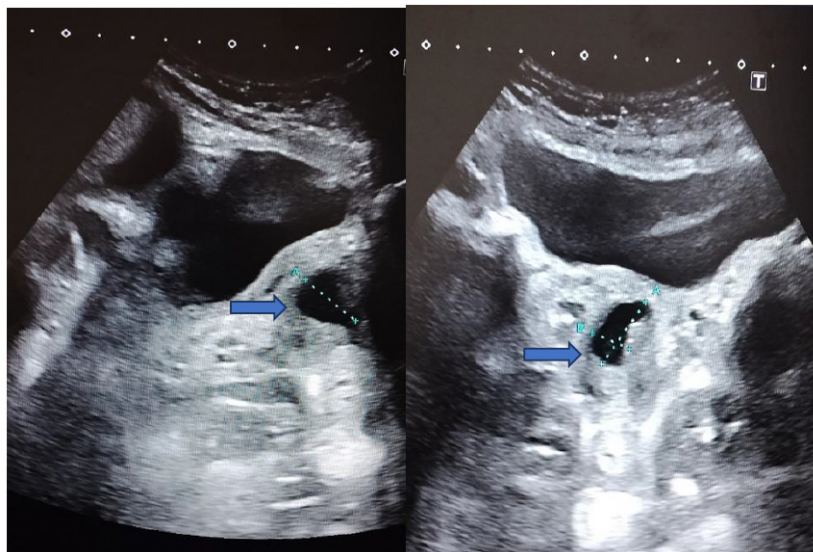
(a, b). Ultrasound showing a cystic formation with thickened walls arising from the urethra.
